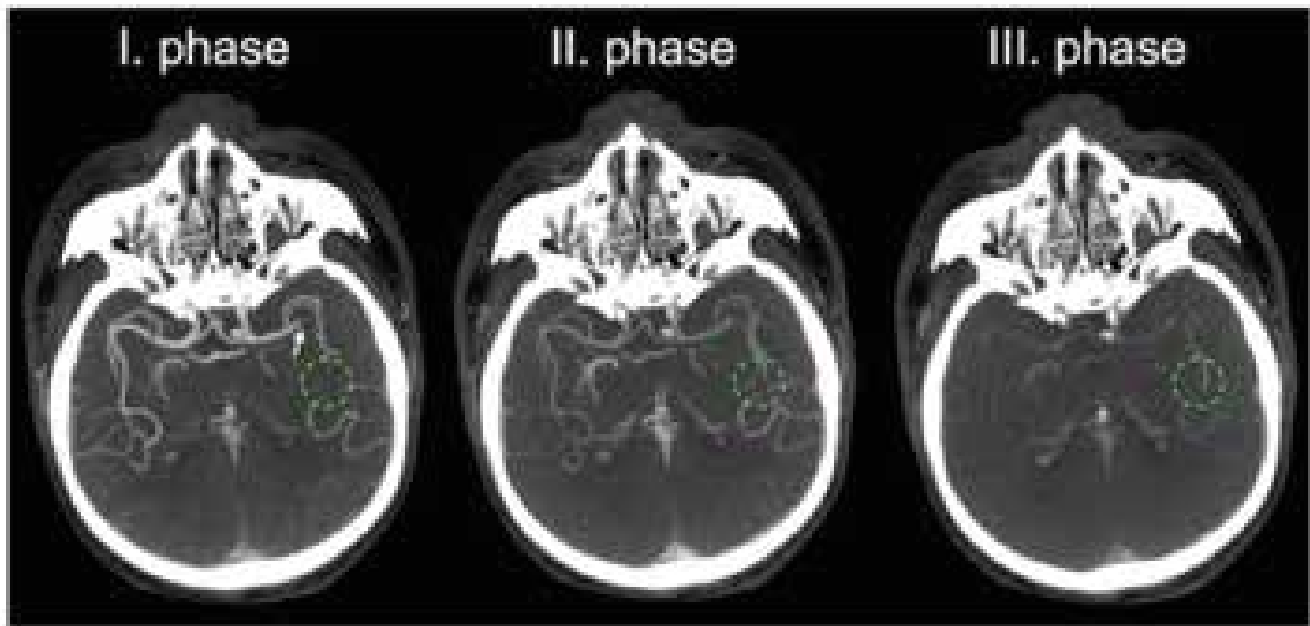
Multiphase CTA in distal or secondary clot detection in MCA. The primary occlusion localized in the distal M1 segment of the left MCA (white arrow) is well detectable on the first phase of multiphase CTA. The distal clot in one of the M2 branches becomes more prominent in the second and third phase (green circle) due to a delayed pial arterial filling within the territory of the occluded artery.
